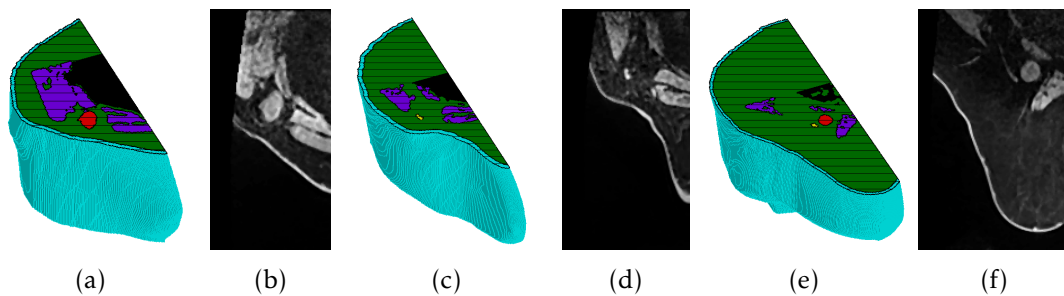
3D representation with a 2D axial view and the corresponding MRI slice of (a,b) AR_001, (c,d) AR_003, and (e,f) AR_005 right axillary region models. Light blue colour represents the skin layer, green represents adipose tissue, purple represents muscle, black represents lung cavity, yellow represents healthy lymph node, and red represents metastasised lymph node.
